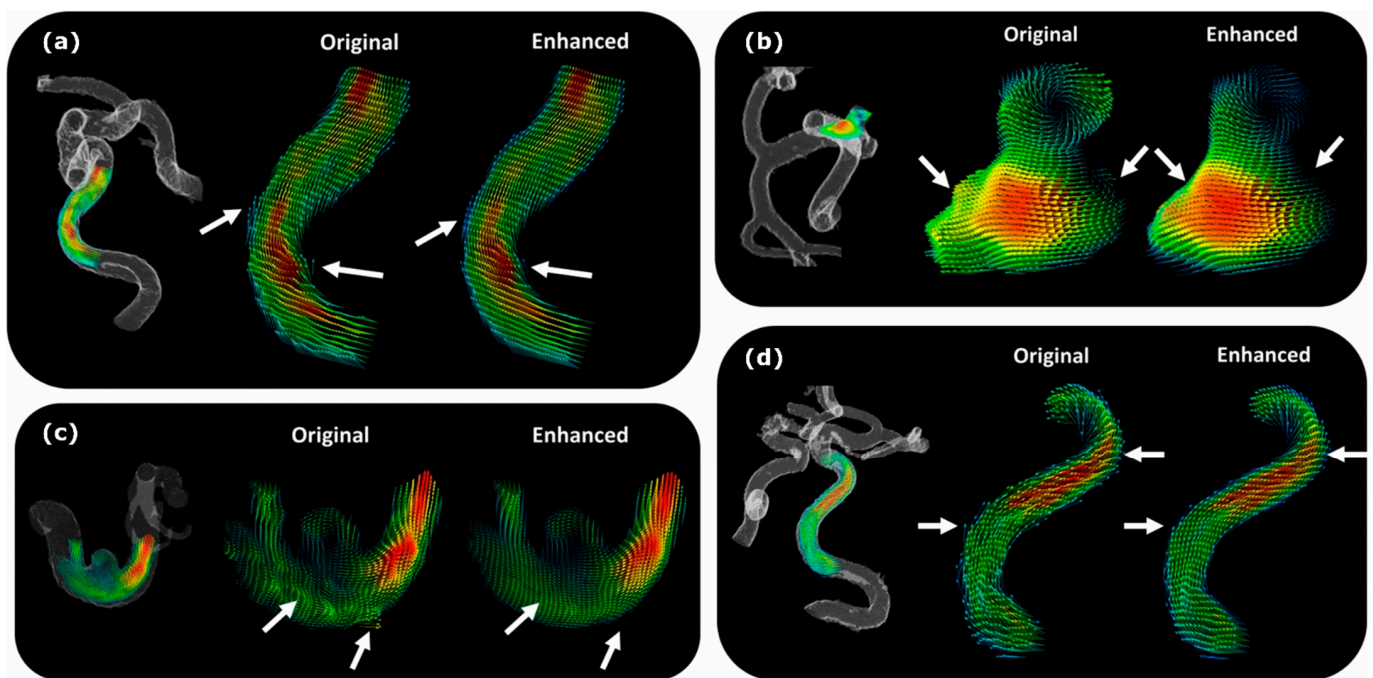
DL models have been used to enhance the velocity field obtained by 4D flow MRI by (a) improving near-wall velocity gradients, (b) smoothing velocity gradient transitions, (c) removing unrealistic velocity fluctuations, and (d) better characterizing near-wall velocity vectors in tortuous structures. Arrows show the main areas of image improvement. Adapted from ref. [80].
